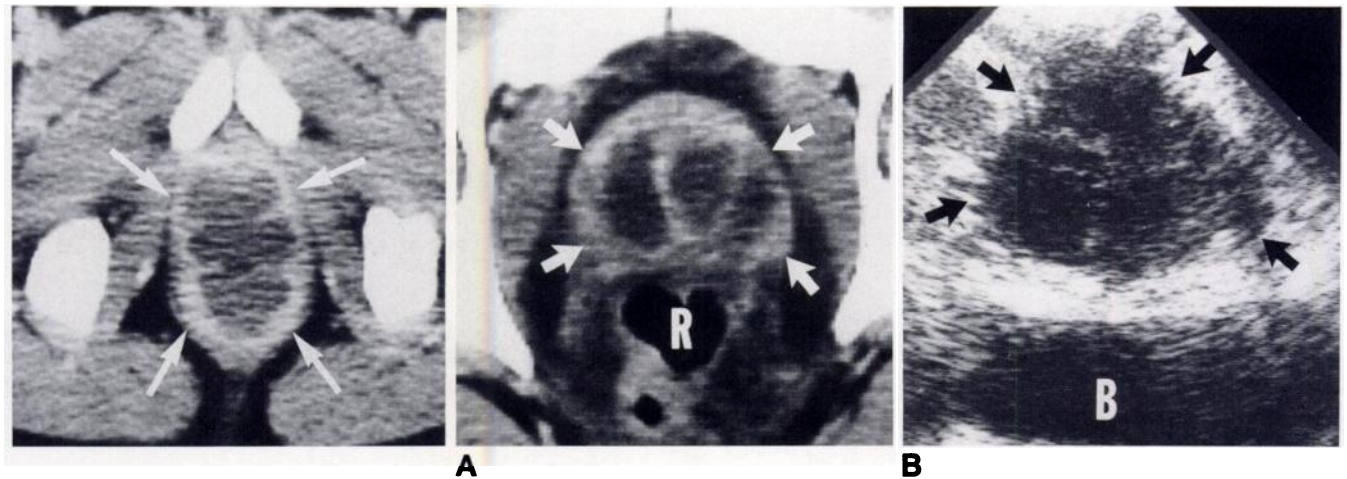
Prostatic abscess in a 29-year-old man with fever, dysuria, and urinary tract infection. CT scan at level of prostate shows an enlarged gland with a partially septated fluid collection with enhancing rims (arrows).
